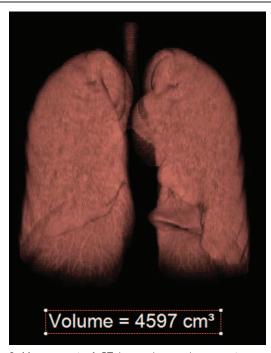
Measurement of CT lung volume using an autosegmentation technique. The lung parenchyma is semiautomatically extracted from CT images using a commercially available reconstruction program (Aquarius iNtuition version 4.4.6; TeraRecon). A 3-dimensional lung volume image is reconstructed using an automatic segmentation technique by a default range of -200 to -1024 HU. Then the CT lung volume is measured. CT = computed tomography.
